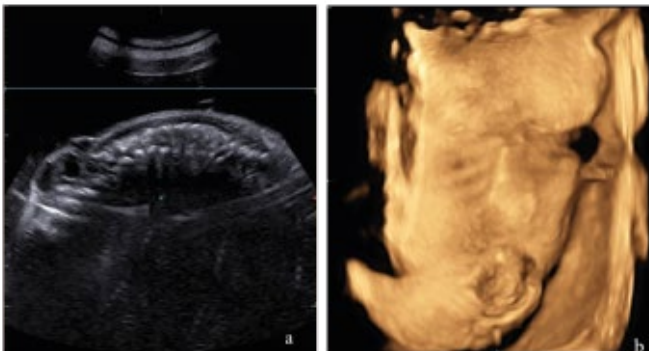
a) 2D ultrasonographic image showing lumbar meningocele b) 3D ultrasonographic image showing lumbar meningocele
